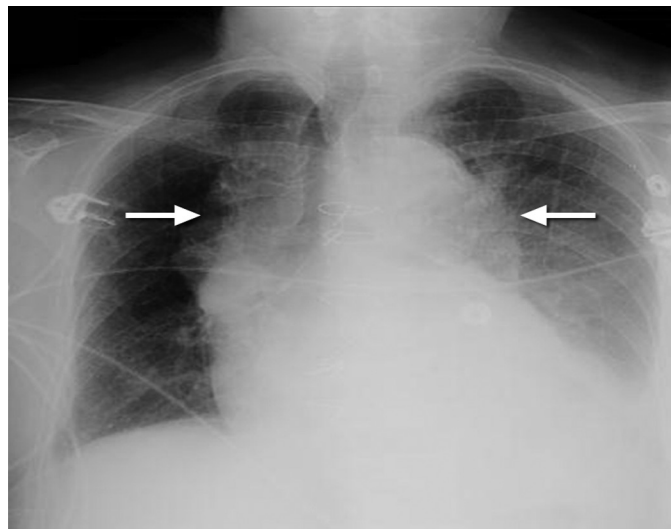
FIGURE e57-7 Chest radiograph of a patient with acute type A aortic dissection demonstrating a widened mediastinum and enlargement of the ascending and descending aortic shadows (*arrows*).
